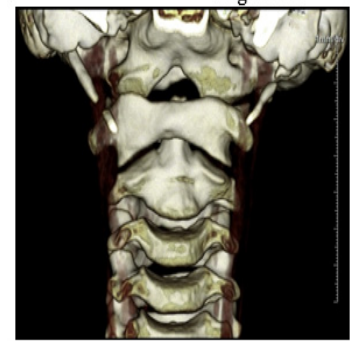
Post reduction CT imaging (F, G) demonstrates successful reduction, with resolution of C1-C2 rotatory subluxation.
